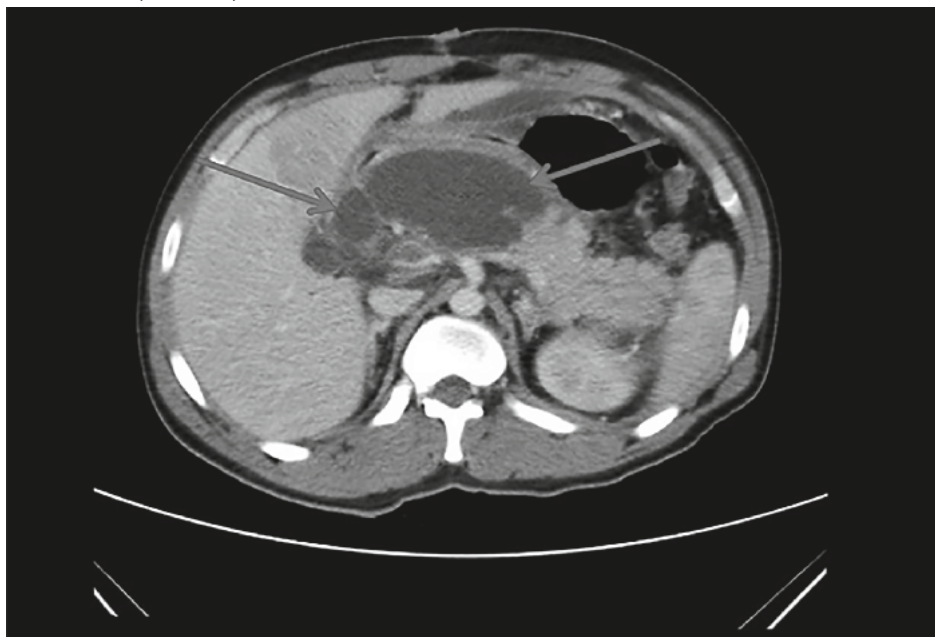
Computed tomography. *Pseudocyst of the head of pancreas.*
